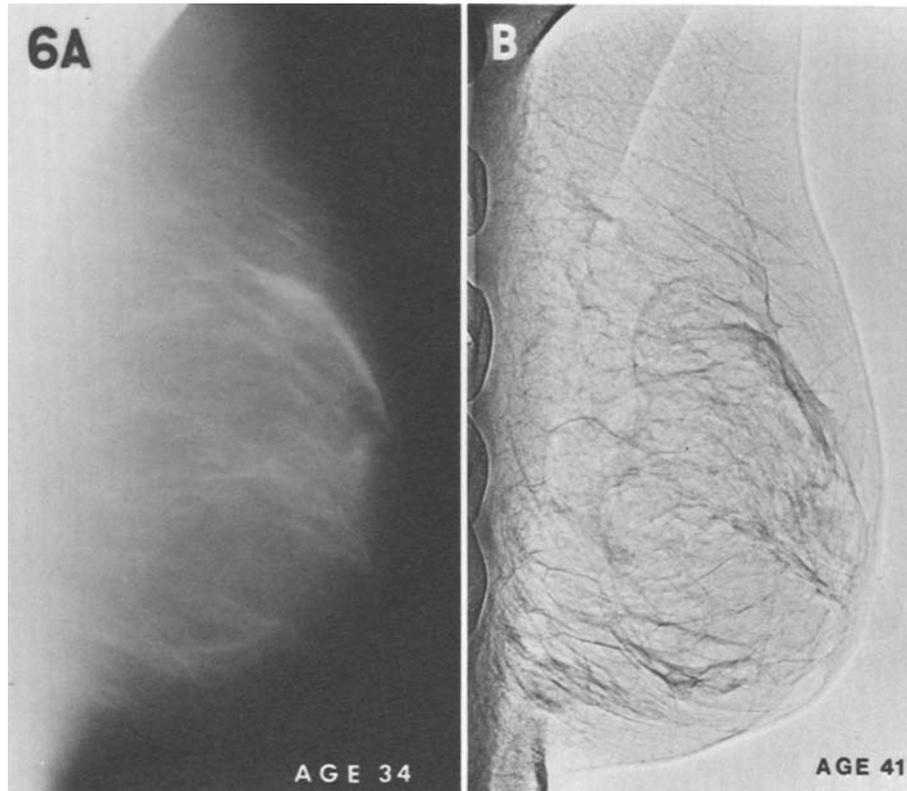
Radiographs taken 7 years apart. No changes have occurred in the parenchyma, which is basically composed of fat. Both studies would be considered to represent an N1 classification.
